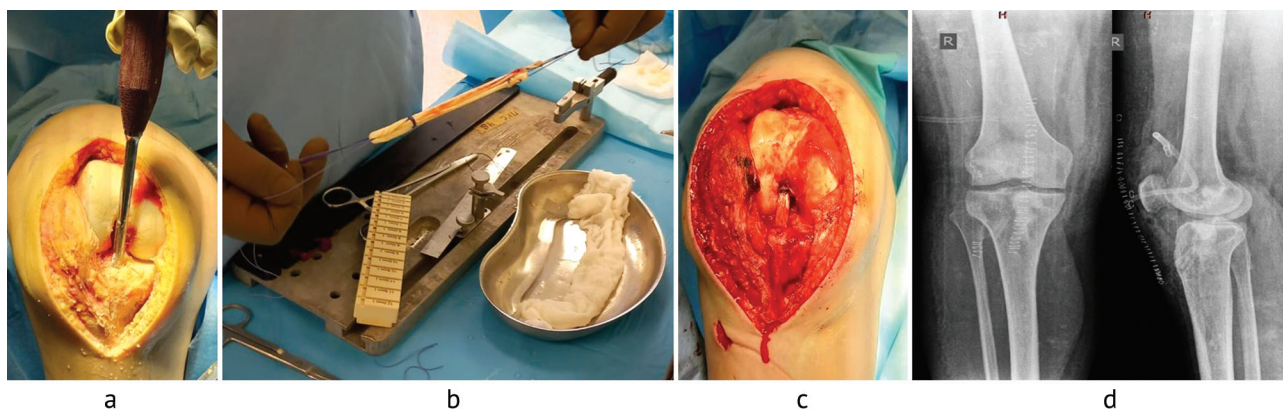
The second stage of treatment: (a) plastic surgery of bone defects of the femur and tibia with allograft chips; (b) preparation of the ACL autograft from the tendon of m. peroneus longus dexter (length, 10 cm; diameter, 8 mm); (c) fixation of the ACL autograft in the femoral and tibial canals with fixation implants; (d) radiographs of the right knee joint in the frontal and lateral projections after the second stage of treatment
